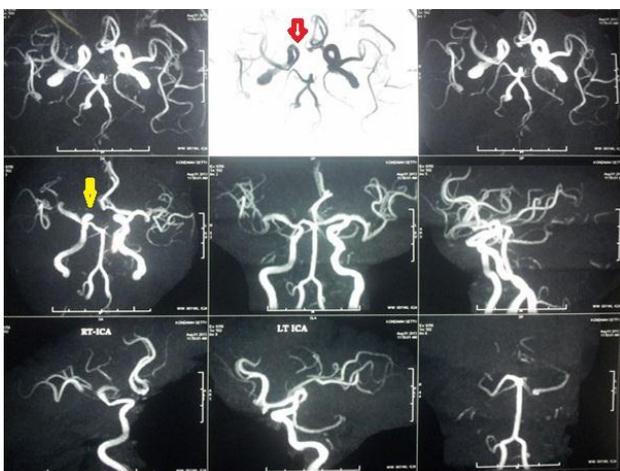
CT angiogram showing hypoplastic right ACA (red and yellow arrows).
